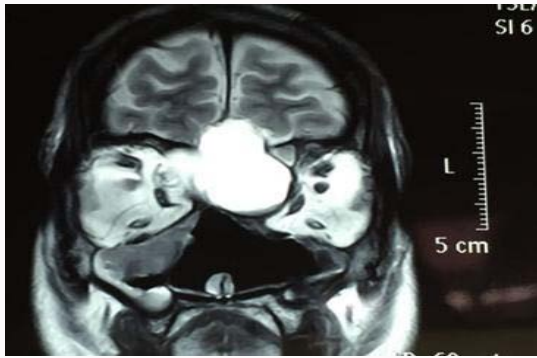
Coronal section MRI of nose and pns showing cystic mass occupying frontoethmoid region with intracranial extension (arrow).
